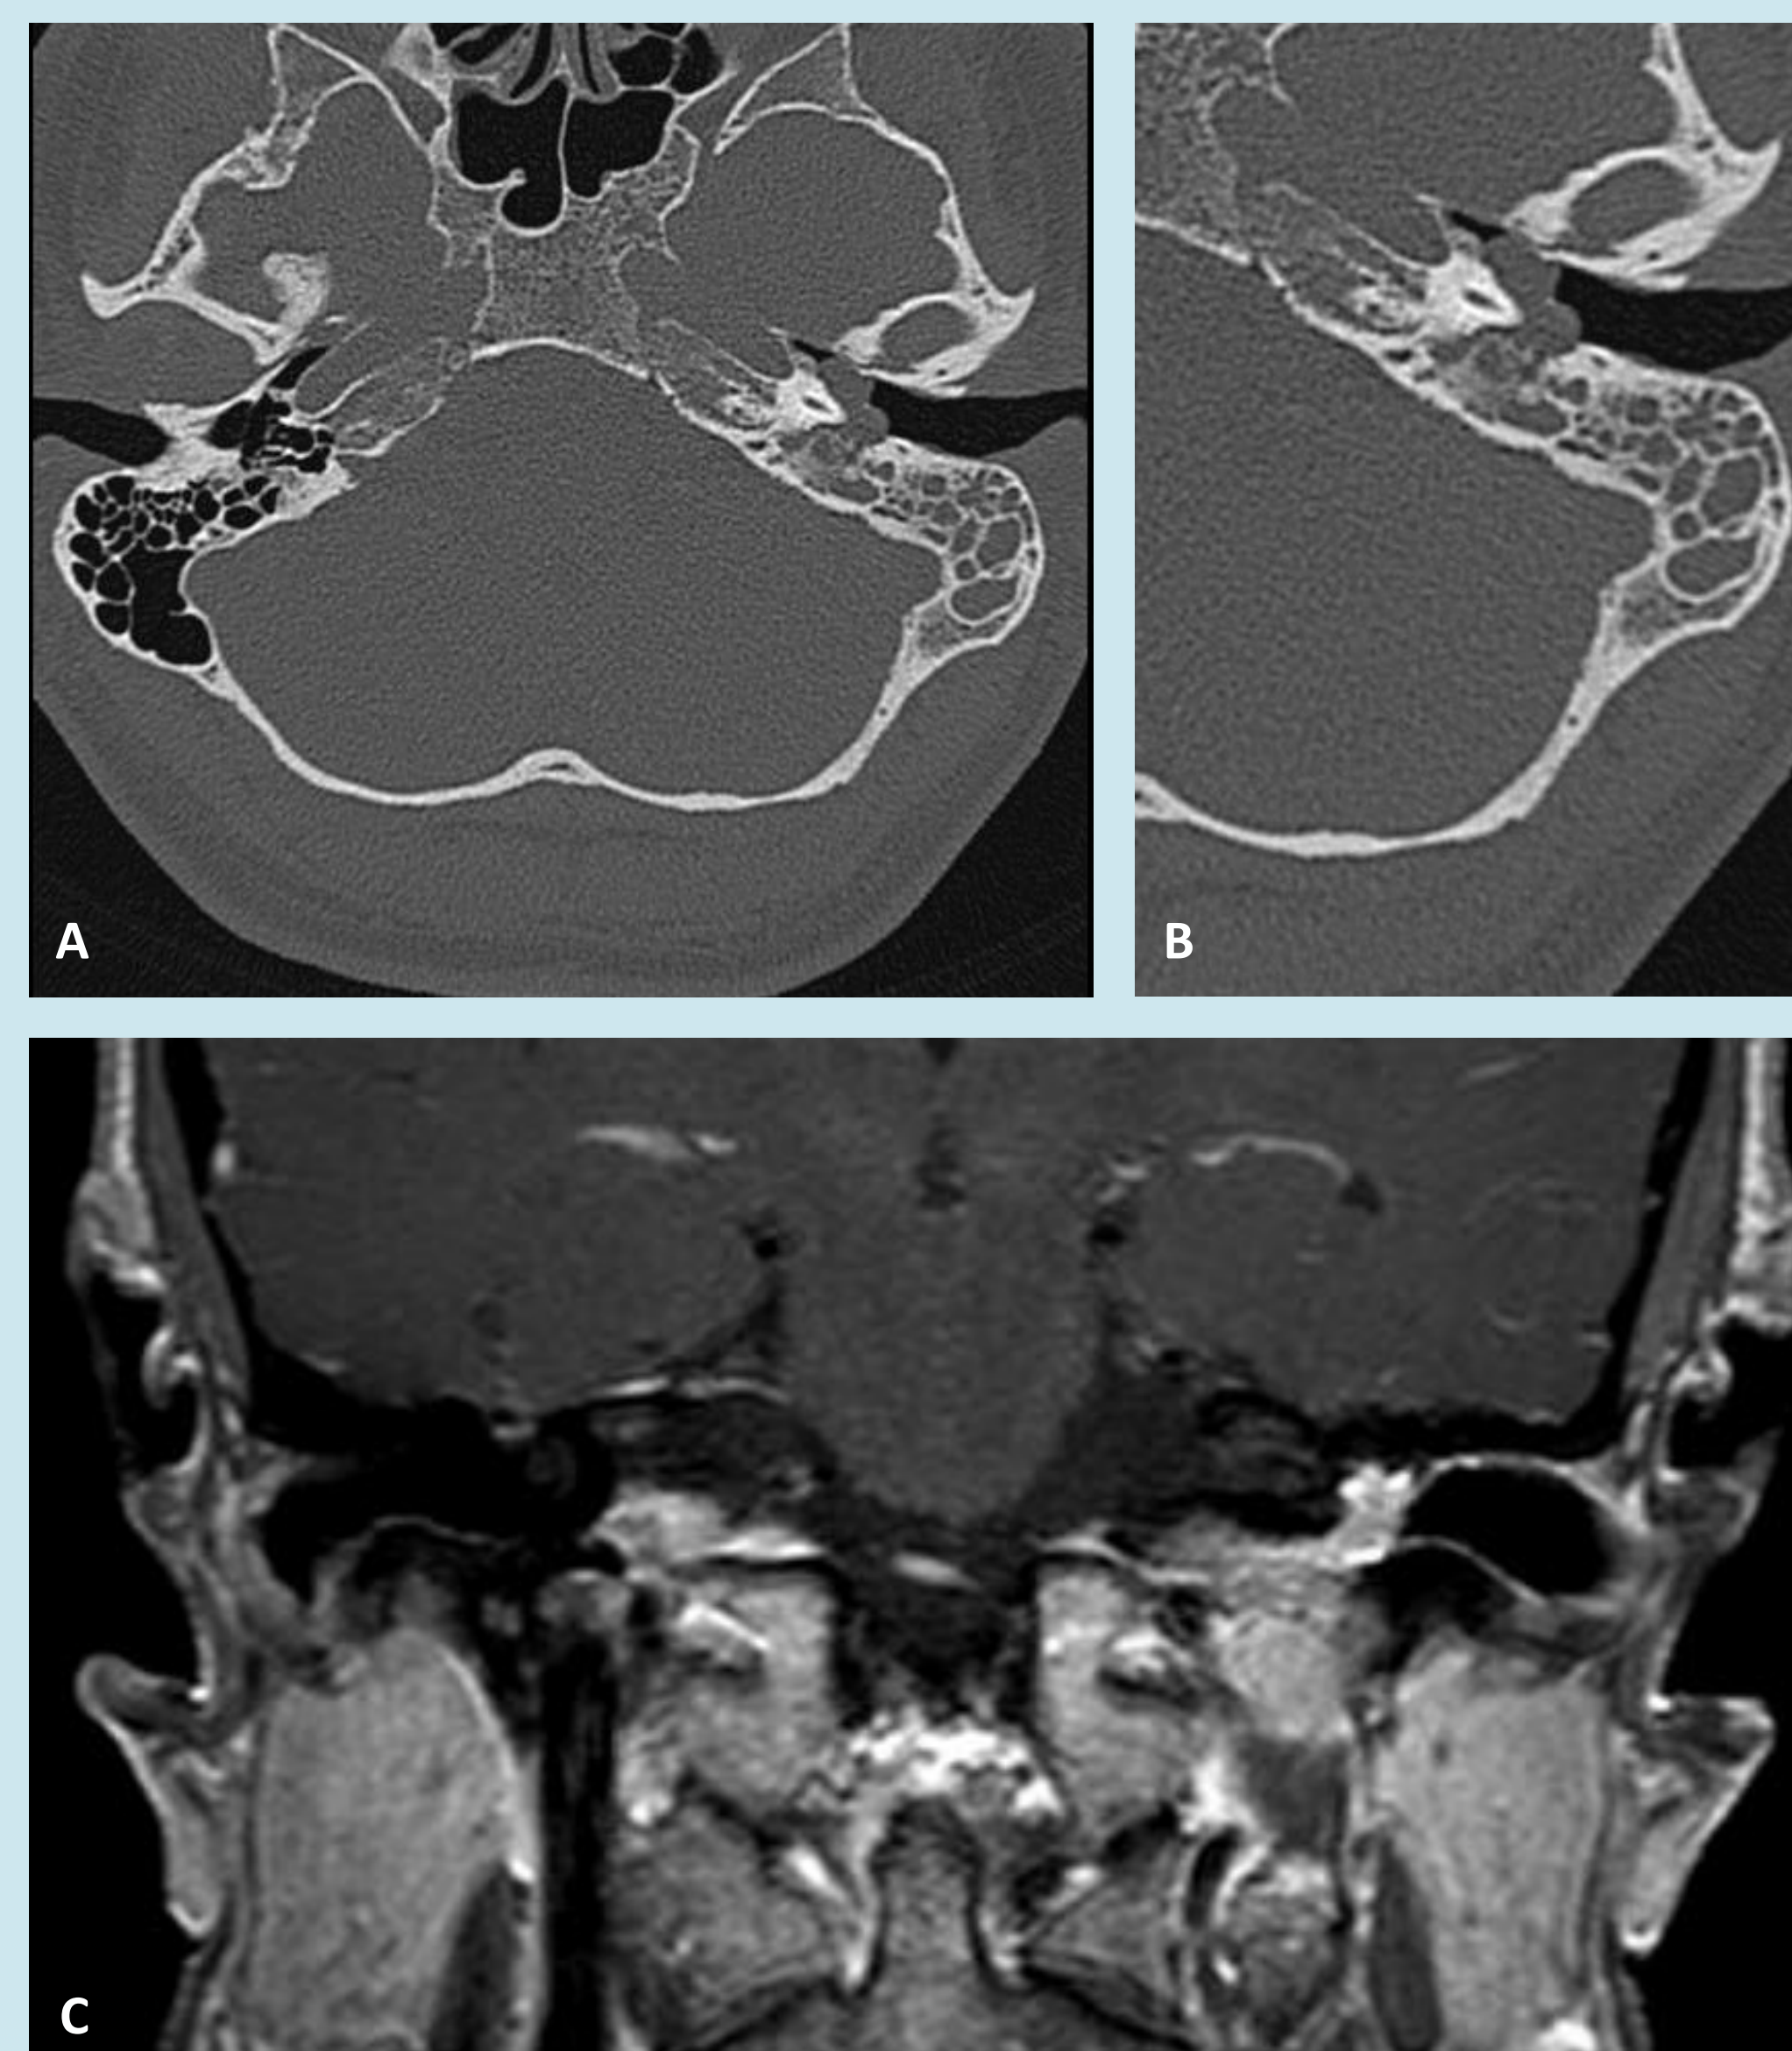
Enhancing soft tissue mass of left middle ear cavity as seen on computed tomography (A, B) and magnetic resonance imaging (C).
